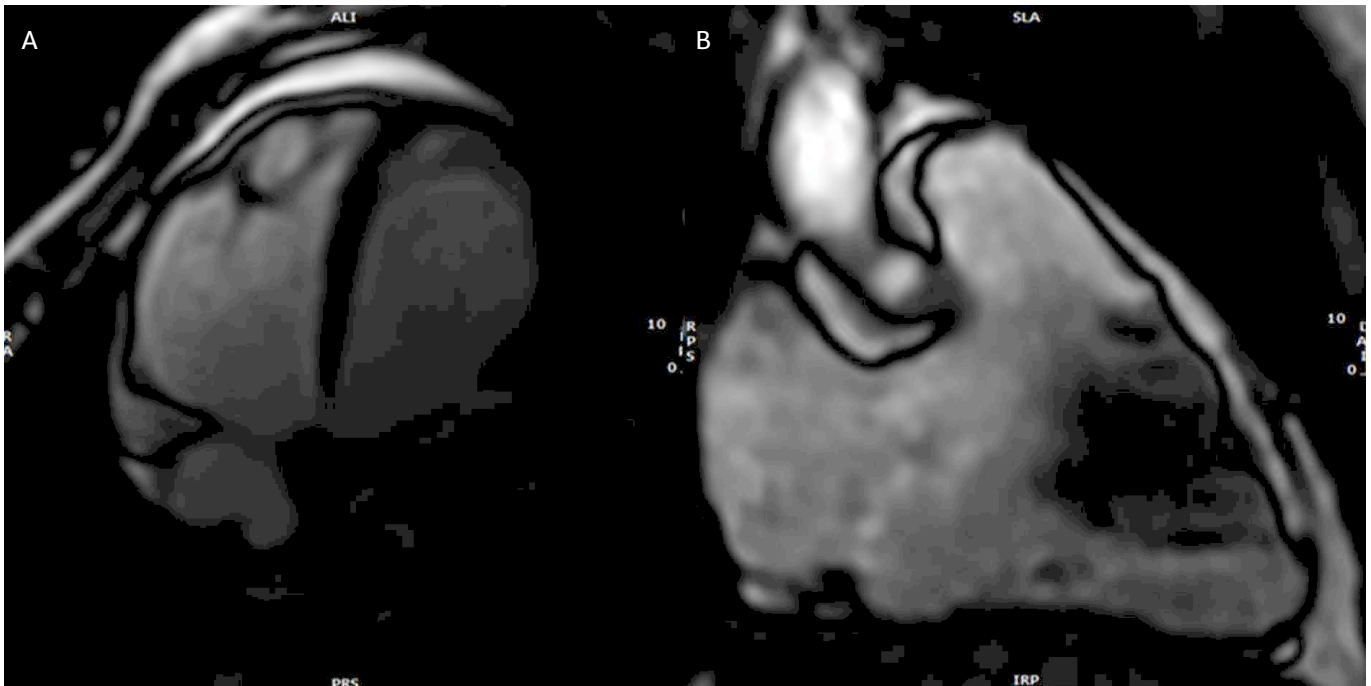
MRI scans from our cases. A. Apical 4-chamber view of cardiac MRI scan of the first patient reveals biventricular dilatation. B. Right ventricular vertical long-axis view scan in our second patient shows dilated right ventricle, with elevated indexed volume.
